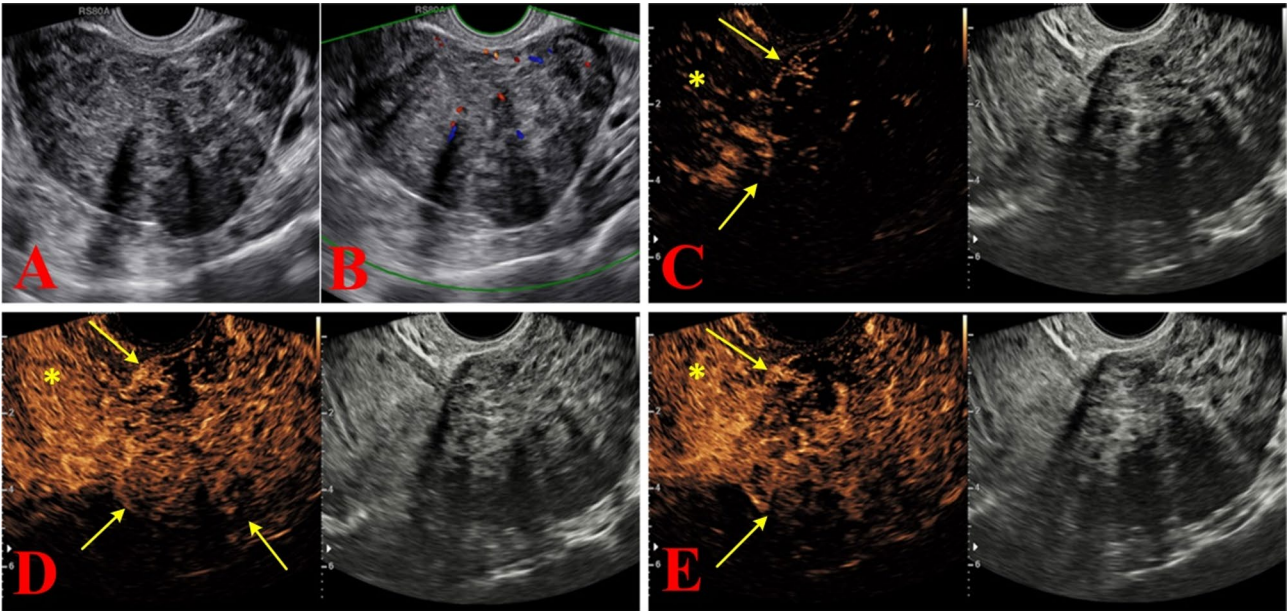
Ultrasonographic images of the thecoma in a 52-year-old woman. The level of HE4 was 36.8 pmol/ml. (A) The ultrasound image shows an irregularly shaped solid mass in the right adnexal region, and (B) the color Doppler ultrasound reveals a small amount of blood flow signals within the lesion (color score = 2), which was classified as O-RADS US v2022 category 5. (C, D) CEUS images of the lesion show synchronous enhancement (arrows in C, score = 2) and hypoenhancement (arrows in D, score = 1) in comparison with myometrium (*). (D, E) Compared with the myometrium (*), the lesion shows a dynamic change in enhancement from hypoenhancement to hypoenhancement (score = 0). The CEUS score was 3, and this lesion was downgraded to O-RADS US v2022 category 4. With the combination of the HE4 level, it was sub-classified as category 4a
